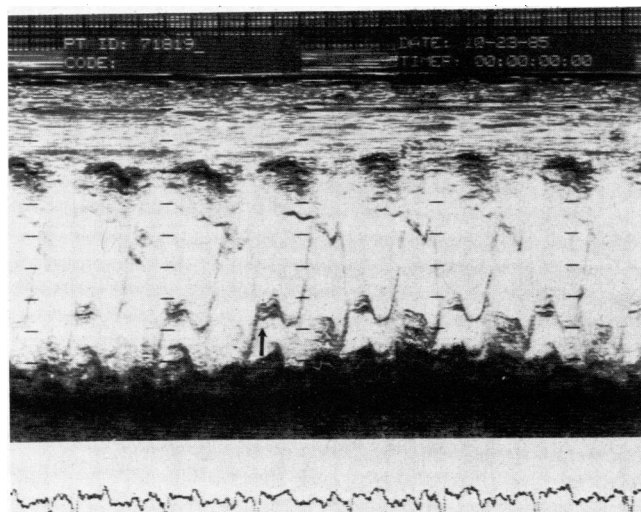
Arrow indicates echocardiographic evidence of mitral valve prolapse (courtesy of Department of Cardiology, Northridge Hospital, Northridge, Calif).
